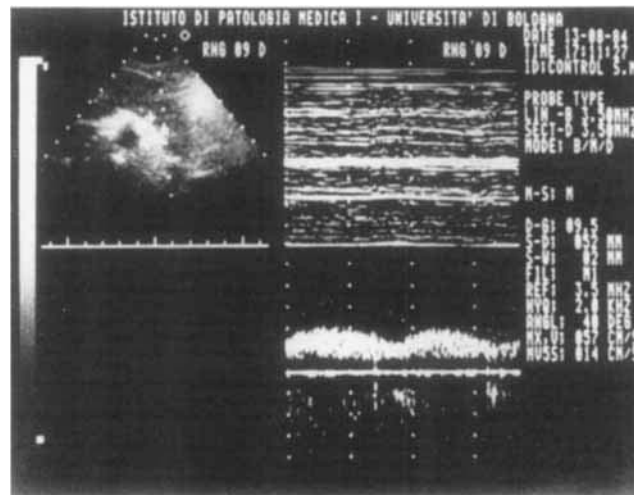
Echo-Doppler measurement of blood velocity in the splenic vein in its ascending tract. The echo-Doppler spectrum (right) appears to be wavy continuous.
